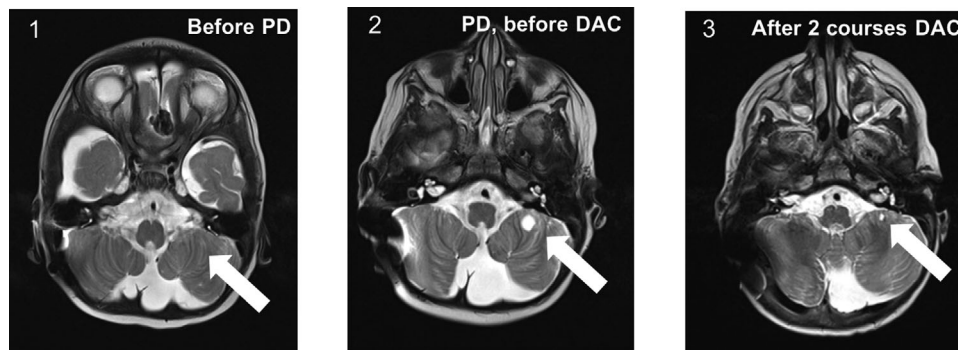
Exemplary imaging in a responder. MRI (axial T2 with contrast) of patient #10 from 2 months before initiation of decitabine therapy and during first-line therapy, showing no cerebellar lesion (1); 3 weeks before initiation of decitabine therapy showing a new metastatic lesion in the cerebellum (2) and following 2 courses of decitabine plus conventional chemotherapy showing regression of the lesion (3). DAC, decitabine; PD, progressive disease; MRI, magnetic resonance imaging
